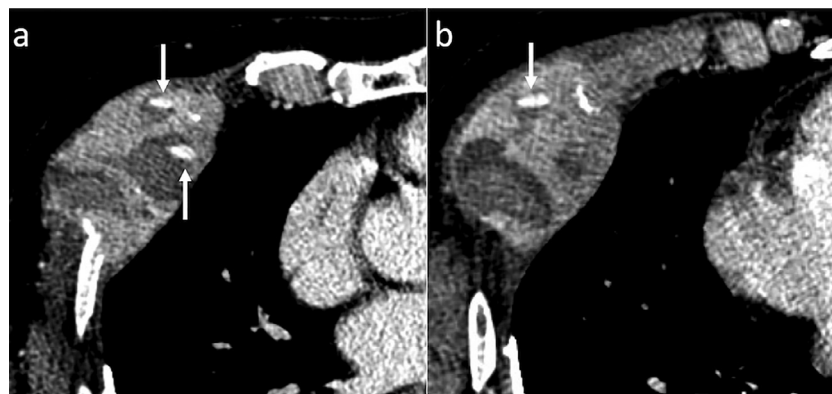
Thoracic computed tomography (CT) on admission. Arterial phase of contrast-enhanced CT (A, B). Some arterially enhancing masses were observed in the right fifth rib, indicating HCC metastasis. Intratumoral hemorrhages are also seen (arrows).
